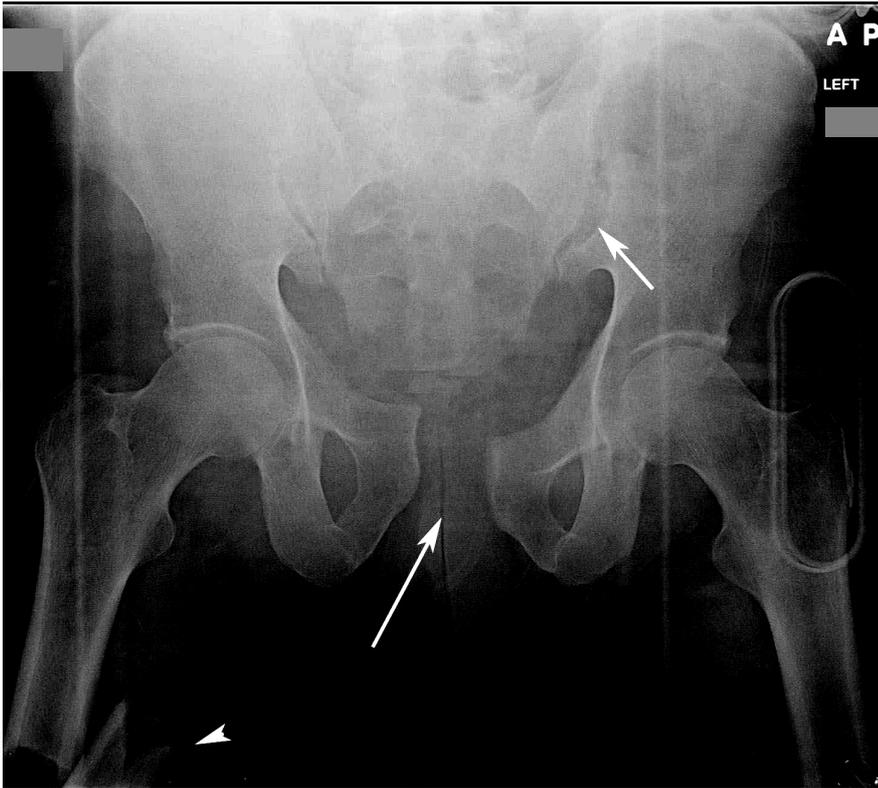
pelvic radiograph shows widening of symphysis pubis (long arrow), widening of left sacroiliac joint (short arrow) and a displaced fracture of the right femoral shaft (arrowhead).
